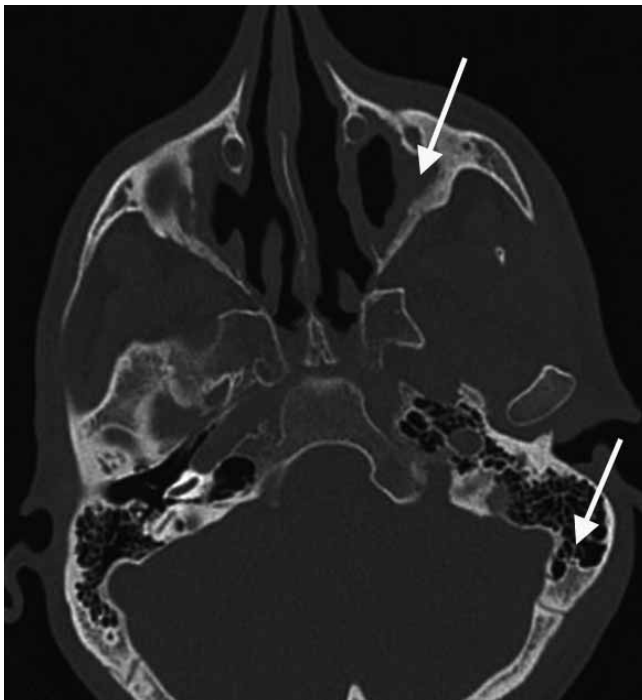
Axial CT scan with hypoplastic maxillary sinuses and extensive temporal bone pneumatization posterior to the sigmoid sinus in a patient with hypoplastic maxillary sinus.
